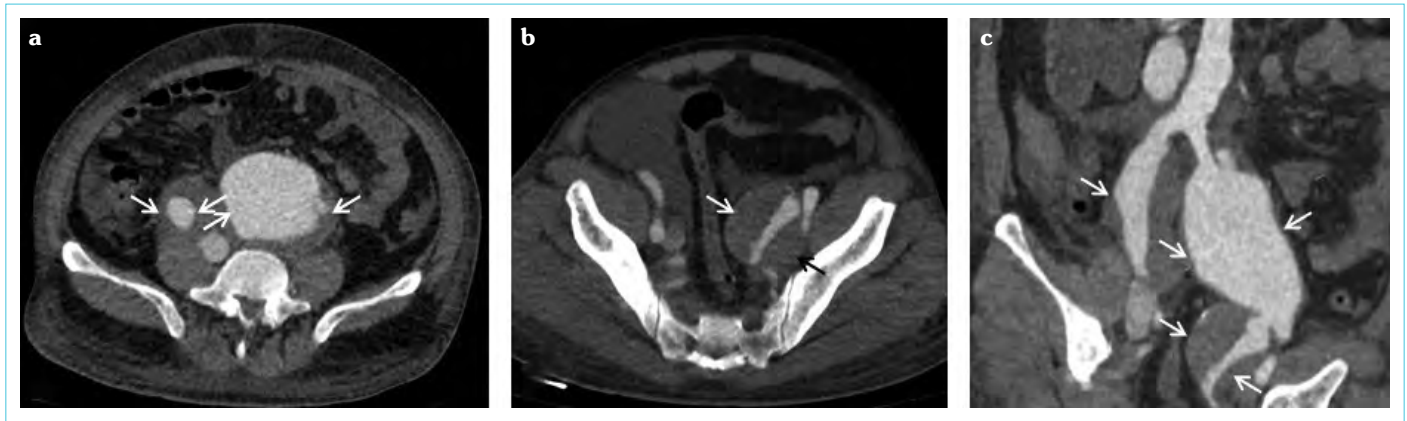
Axial (a, b) and curved MPR (c) CT angiography images show bilateral; partially thrombosed common iliac and left internal iliac artery aneurysms (arrows)
